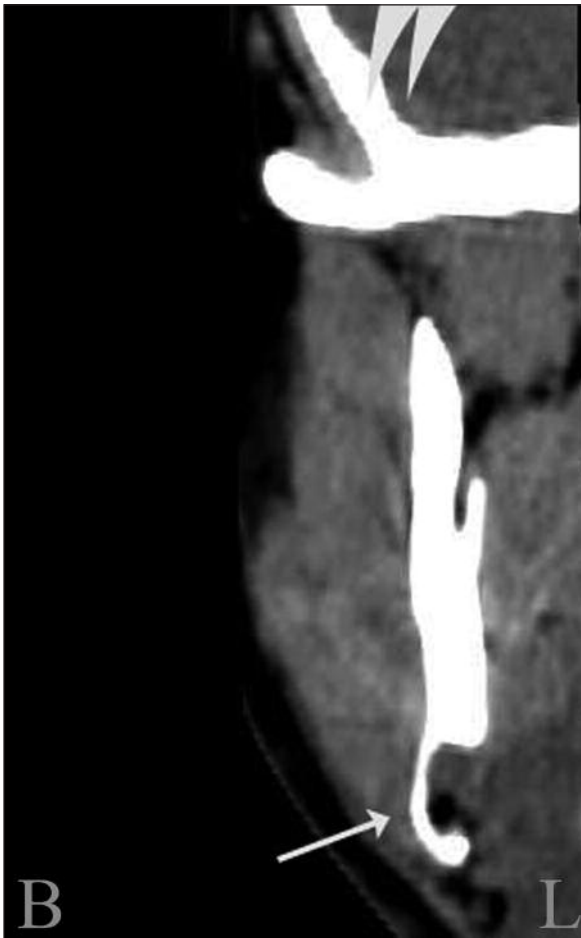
Axial CT scan of the mandible with bucco-lingual reconstruction program showing the sharply demarcated lesion, affecting the lingual surface of the mandible.
